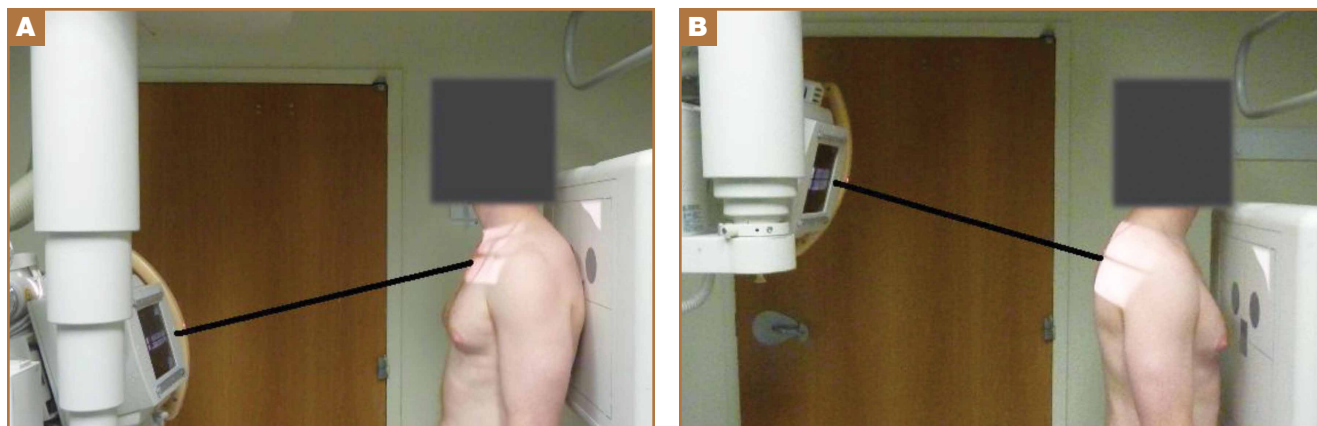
Clinical example: (A) 15° cephalic angulated anteroposterior radiograph and (B) 15° caudal angulated posteroanterior radiograph.
